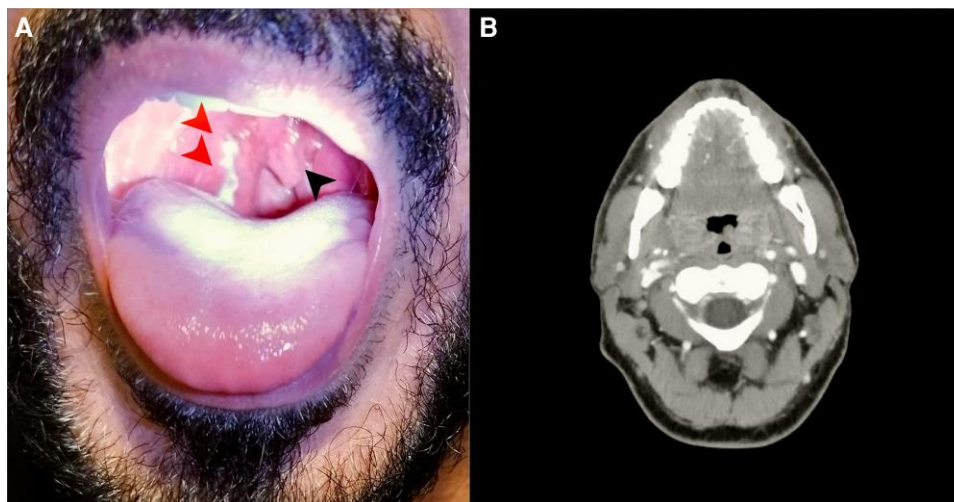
Extracutaneous manifestations in mpox infection. This patient exhibited skin lesions and pharyngeal involvement, experiencing pain and swallowing difficulties. Hospitalization was necessary, with observed improvement after treatment with tecovirimat. *A*, Clinical image displaying pharyngeal involvement with exudate (*red arrowheads*), along with a slight deviation of the uvula (*black arrowhead*). *B*, Computed tomographic scan revealing pharyngeal edema without airway compromise.
